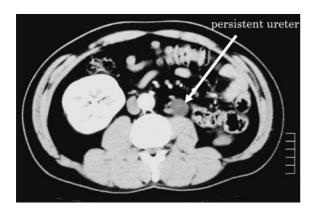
CT shows left renal agenesis and a retroperitoneal cystic lesion.
